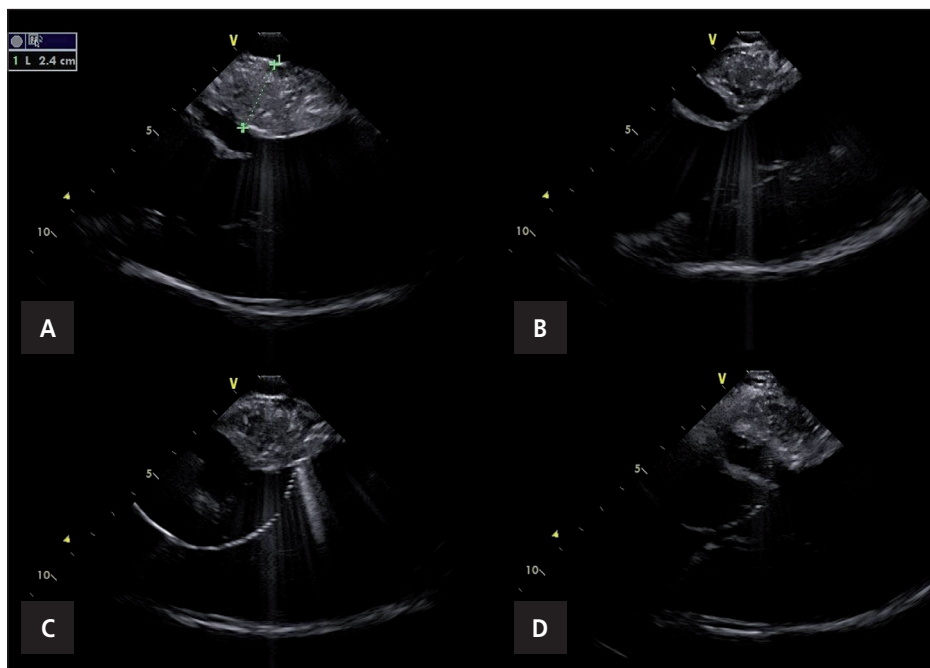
Intracardiac echocardiography (ICE) images during hypertrophic obstructive cardiomyopathy (HOCMP) catheter ablation. ICE probe is situated in the right ventricle, you can see interventricular septum (IVS), left ventricle (LV), left ventricle output tract (LVOT), septal leaflet of the mitral valve and left atrium. (A) Measurement of the septal hypertrophy, (B) septal anterior movement (SAM), septal leaflet of the mitral valve is pressed against hypertrophic septum during early systole and obstructs LVOT, (C) ablation catheter on the hypertrophic septum, catheter is introduced transseptally and tip of the catheter is resting on the apical part of the septal hypertrophy region, (D) position of the tip of the ablation catheter on the septum hypertrophy more basally near the aortic valve. The situation after several ablations in this region. Under the surface of the septum in the vicinity of the catheter tip you can see several finished radiofrequency ablation lesions (white regions).
